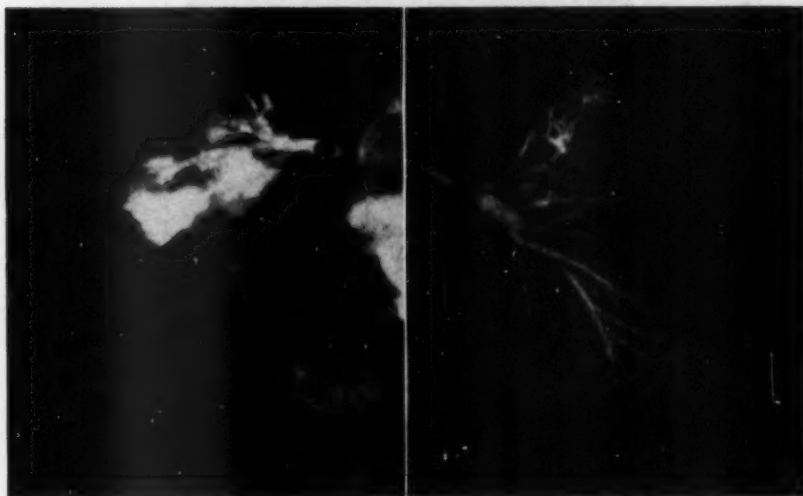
Left, postmortem roentgenogram of the right lung with the right pulmonary artery injected. Only the upper lobe is filled in this lung. Right, roentgenogram of the left lung with the left pulmonary artery injected. The entire pulmonary tree is filled in this lung.
